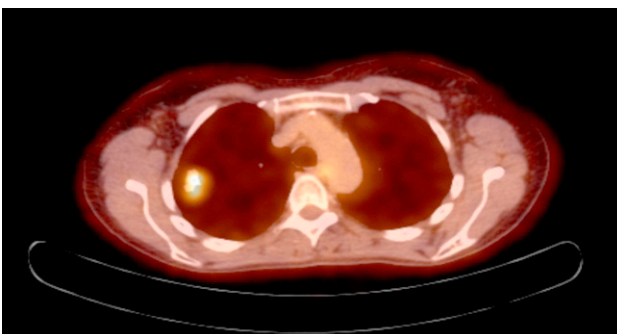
PET CT scan reveals perfectly visible tumor in right lung
